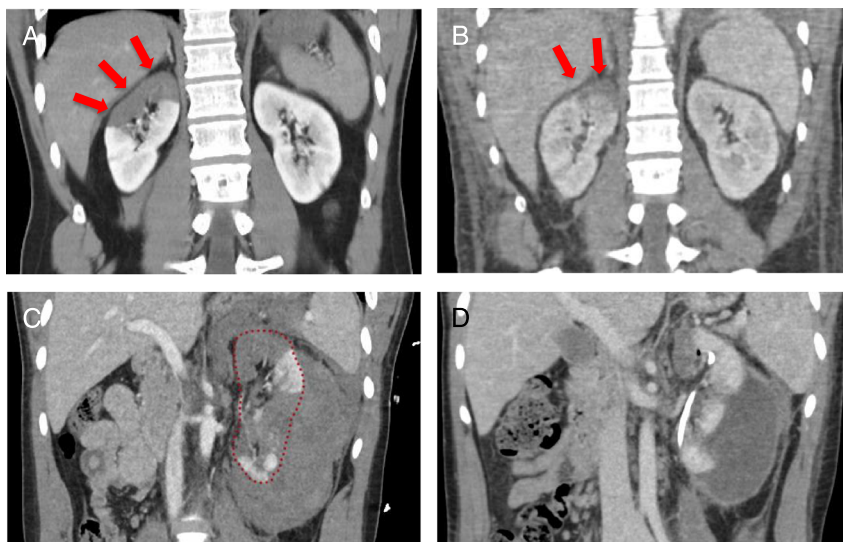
Grading changes between the 1989 and 2018 AAST renal grading systems. *A and B*, Initial trauma CT scan at admission (*A*) showing segmental vascular injury leading to segmental infarction in the right kidney after blunt trauma (red arrows). Follow-up image after 5 days (*B*) shows smaller area of infarction with resolving of the renal injury. The injury was graded as III according to the 1989 AAST grading due to parenchymal lacerations >1 cm without urinary extravasation (not shown) and was upgraded to grade IV according to the 2018 AAST grading due to segmental vascular injury and segmental infarctions without active bleeding. No renal-related interventions were done. *C and D*, Initial trauma CT scan at admission (*C*) showing parenchymal fragments and segmental devascularization of the left kidney with fluid collection around the kidney. The injury was graded as V according to the 1989 AAST grading indicating a “shattered kidney” and was downgraded to IV according to the 2018 AAST grading due to segmental kidney infarctions without active bleeding and also because the renal parenchymal anatomy was still identifiable (red dotted line). Follow-up image at 1 month (*D*) shows more identifiable and vascularized renal parenchyma as well as walled-off fluid collection decreasing in size. No bleeding control renal-related interventions were performed; ureteral stent and perinephric drain were placed to help treat urinary extravasation and perirenal fluid collection.
